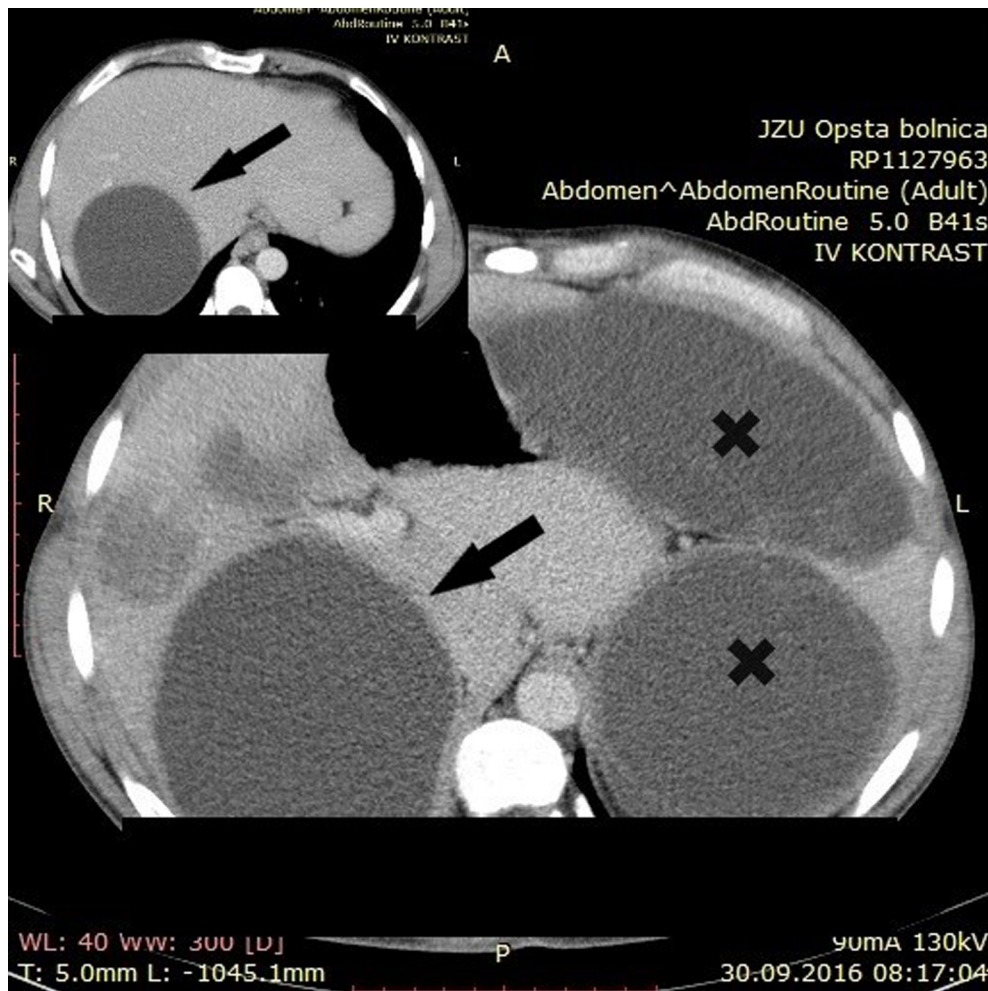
Axial CT scan of the abdomen showing cysts in the abdomen (crosses) and cyst in the right liver lobe (insertion), marked with black arrows.
